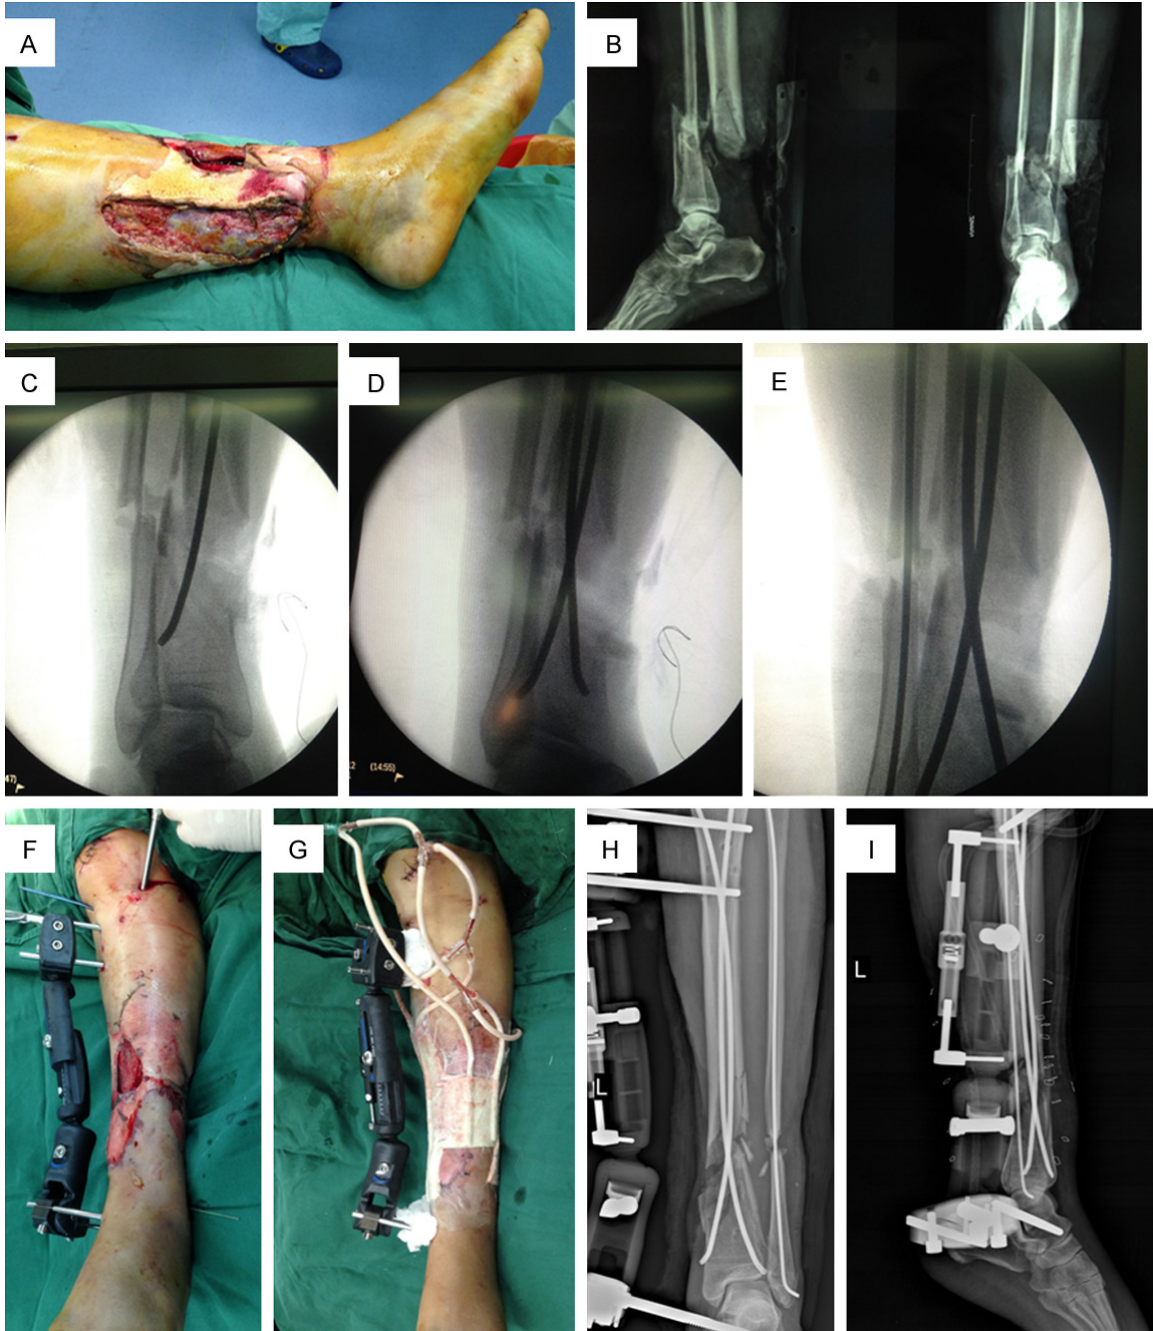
A 50-year-old female with Gustilo IIIB and 43C fracture of the left tibia and fibula, and also sustained an injury of the left femur (A). The X-ray presented a distal tibia and fibula fracture which is not fit for interlocking intramedullary nail because of lock or barrier screws with no enough working length (B). The tibia and fibula fracture was managed by titanium elastic nails and external fixation in sequence (C-F). The photos showed that the vacuum sealing drainage was performed after the fracture was treated with intra- and extramedullary fixation (G). The post-operative X-ray images of this case (H, I).
